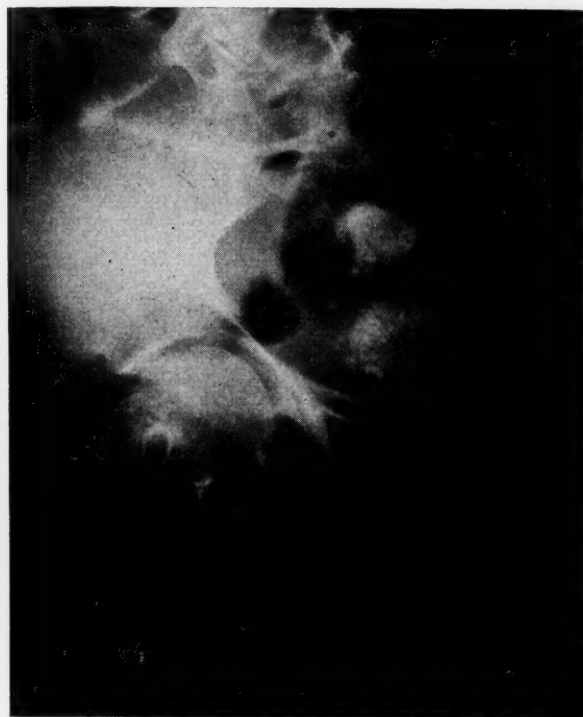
Case 6. Plain roentgenogram showing crushed calculi confined to bladder.
